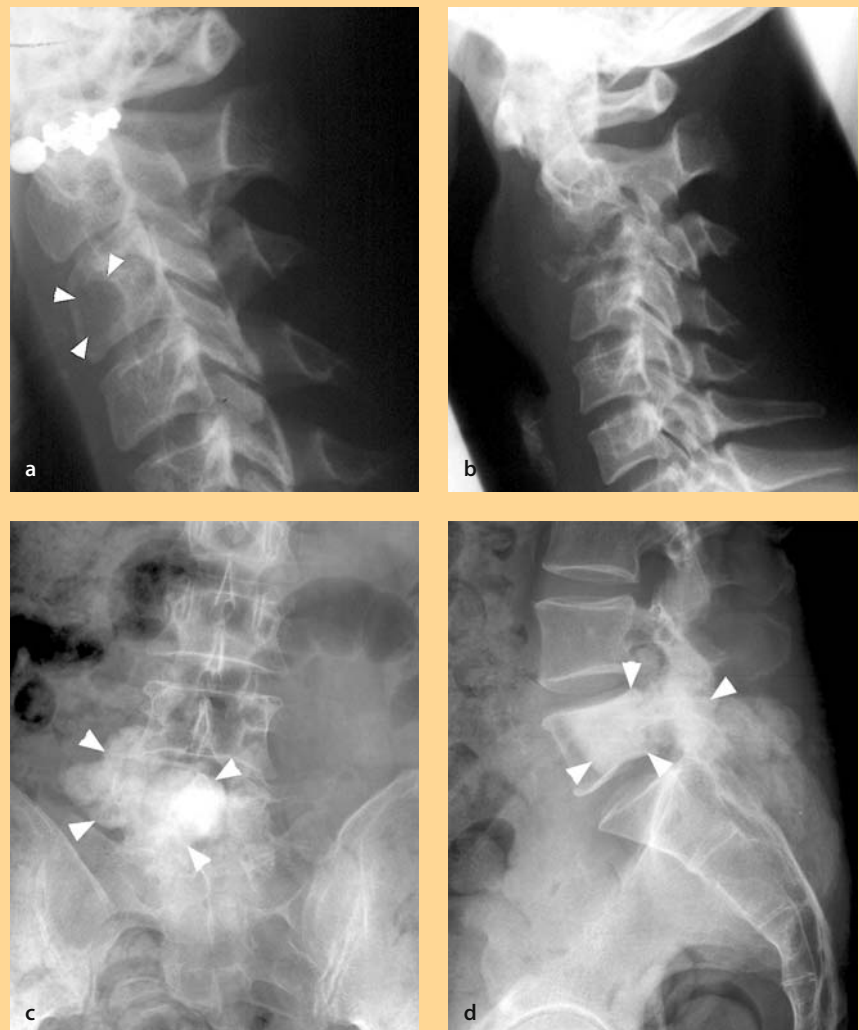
Radiographic findings
